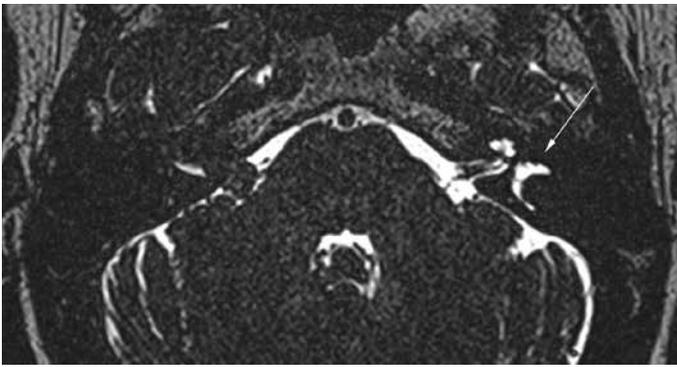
Axial and axial maximum intensity projection (MIP) images obtained with T2-weighted sequences. The characteristic high signal in the left labyrinth (white arrow) is observed. There is no evidence of signal at the site of schwannoma.
